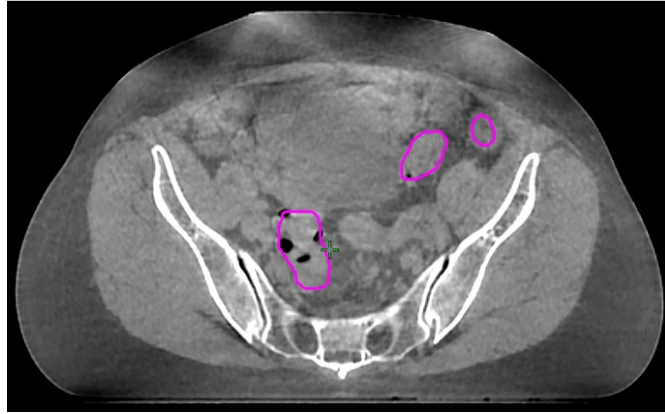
A CBCT slice in one patient with the colon segmented by TotalSegmentator. It is observed that the edges of the segmentations do not coincide with the colon walls. This is particularly evident for the colon loop in the upper right of the CBCT, i.e. the descending colon.
